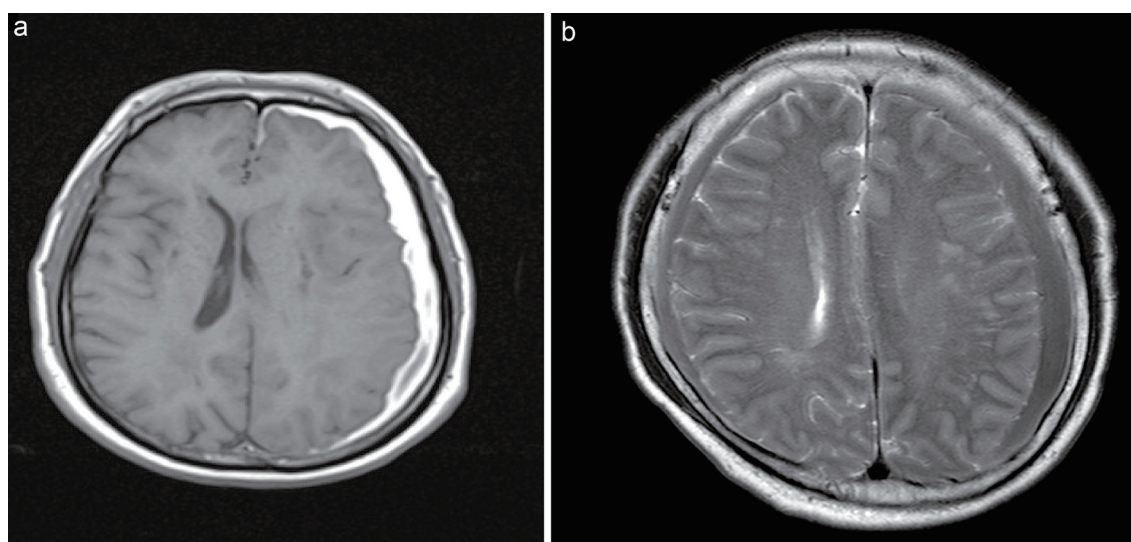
Magnetic resonance images of chronic subdural hematoma. Unilateral (a) versus bilateral (b) hematomas.
